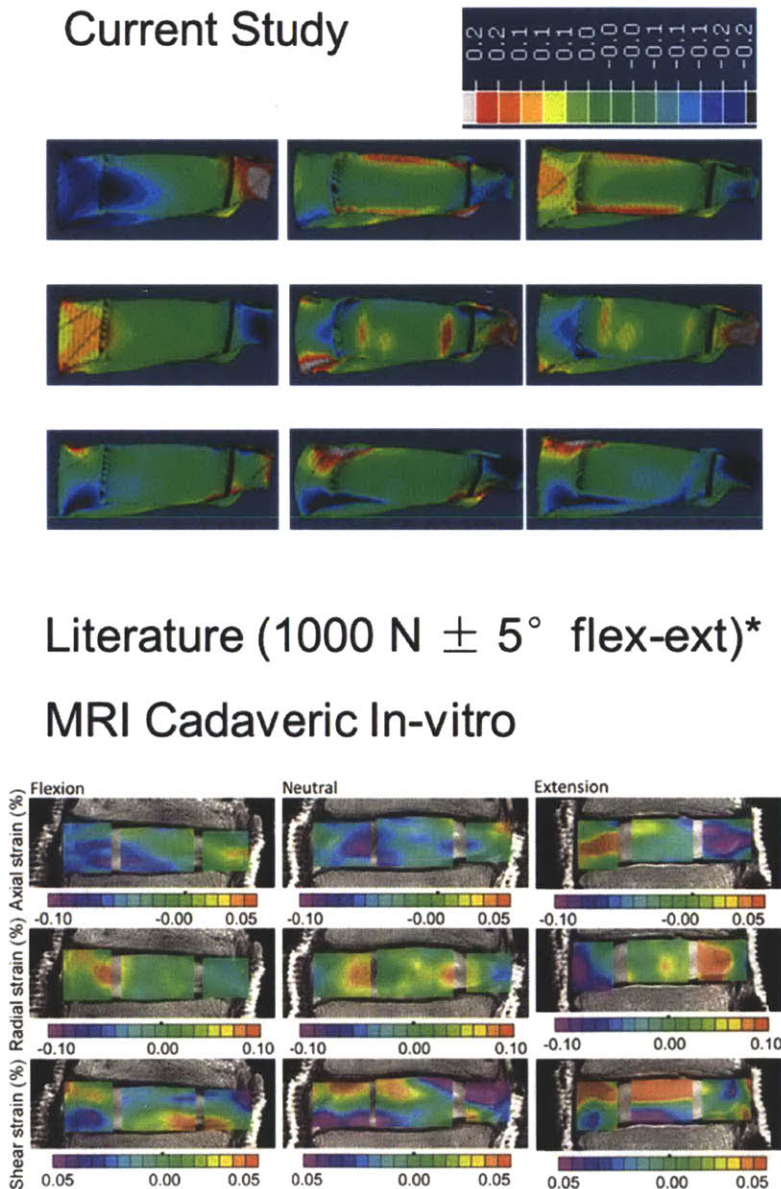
Despite some similarity in strain patterns, our study showed larger AF bulk strains than an *in vitro* MRI study from literature.
